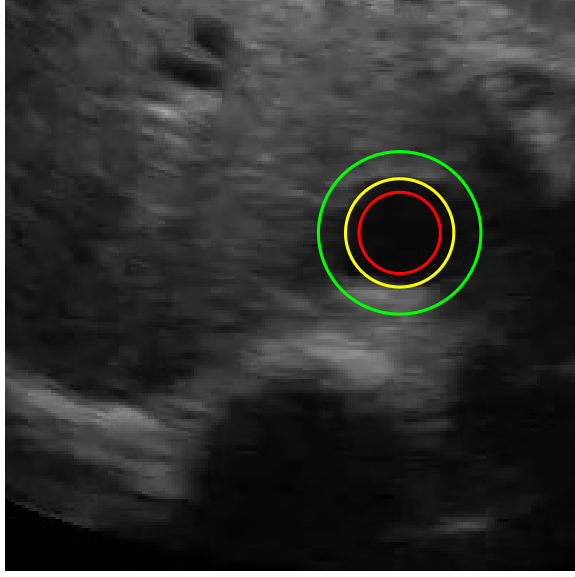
A typical ultrasound image of IVC with circle evolution model.
